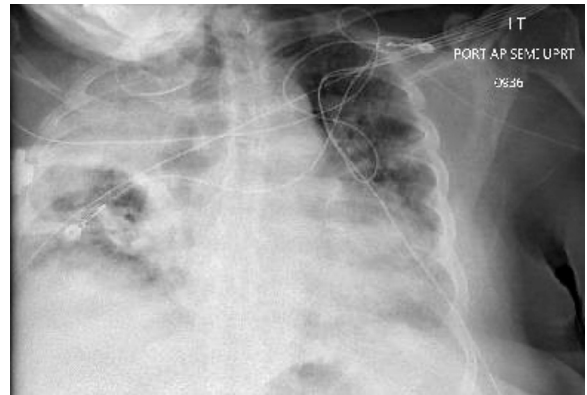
Chest radiograph: right upper lobe collapse
